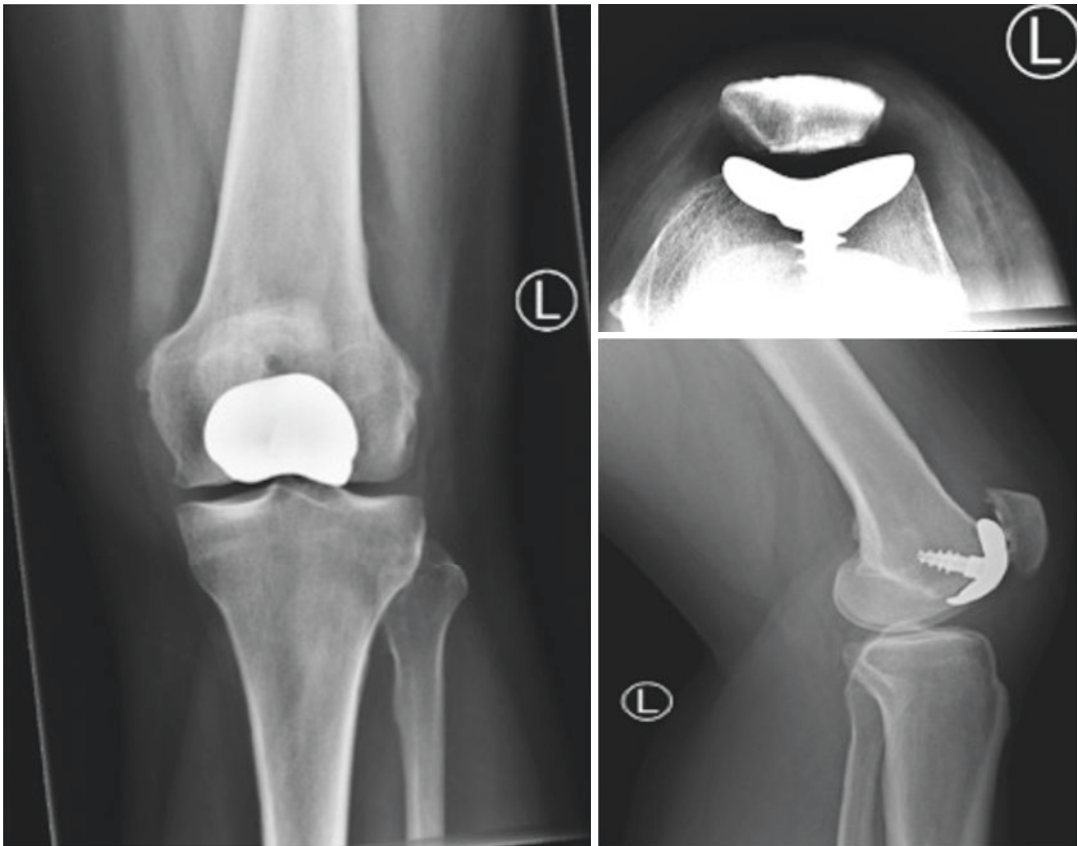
Postoperative radiographs of the inlay implant in three planes are done routinely to check on implant positioning
